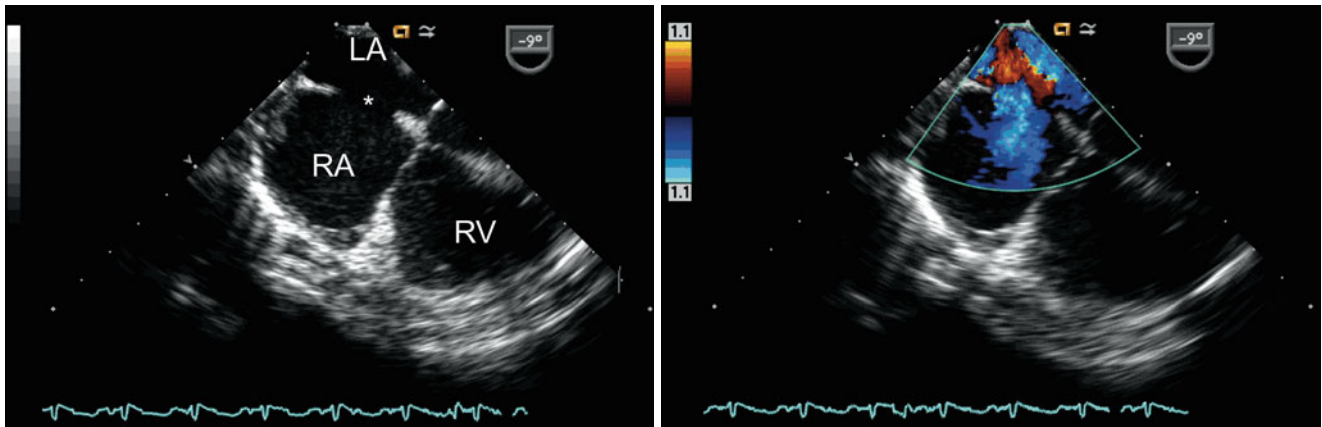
Left panel:* Centrally located secundum atrial septal defect (asterisk) shown as seen in the mid esophageal four chamber view. *Right panel:* Color flow Doppler interrogation demonstrates left-to-right shunting across the defect (blue signal). Note that the probe has been rotated
